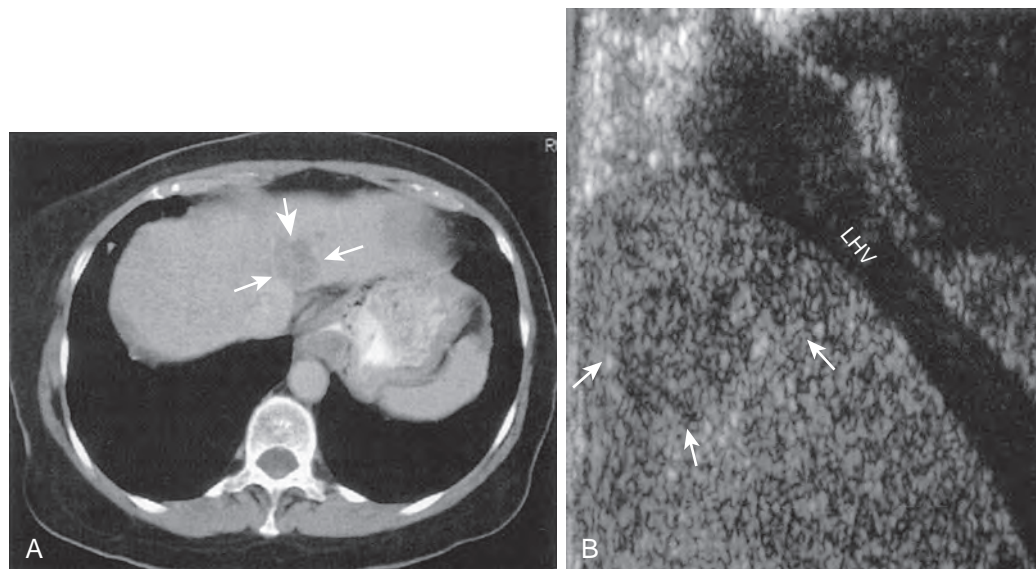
Hepatocellular carcinoma: intraoperative ultrasound and CT. A. CT demonstrates a low-attenuation lesion (arrows) adjacent to combined confluence of left and middle hepatic veins. B. Sagittal ultrasound image during laparotomy confirms that the lesion (arrows) cannot be resected free of the left hepatic vein (LHV). (Courtesy Helena Gabriel, MD, Chicago, IL.)
